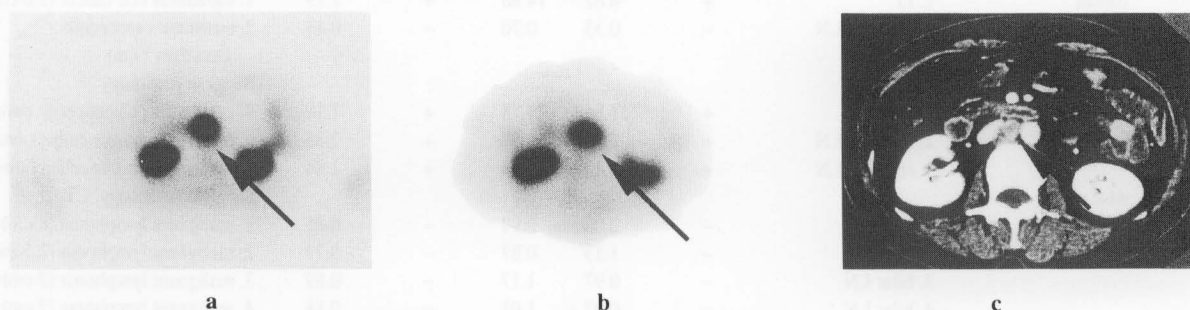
Paraaortic lymph node metastasis in a patient with uterine cancer. Both transaxial FDG image obtained with the dedicated PET camera (a) and that obtained with the dual-head gamma camera (b) revealed a metastatic lymphadenopathy (arrow) showing on the CT image (c).
